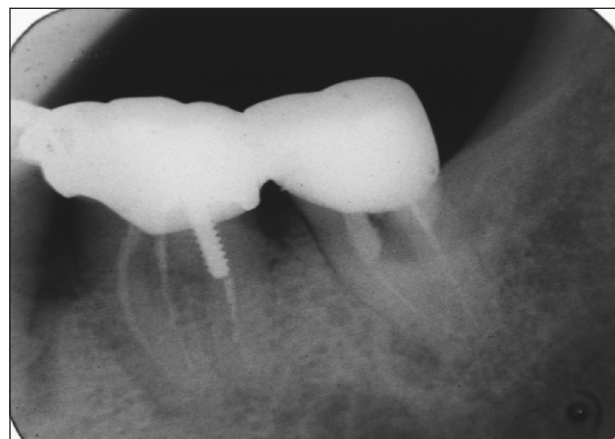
Radiograph at the two-year recall revealed complete resolution of radiolucency around the distal surface of the tooth 37.
